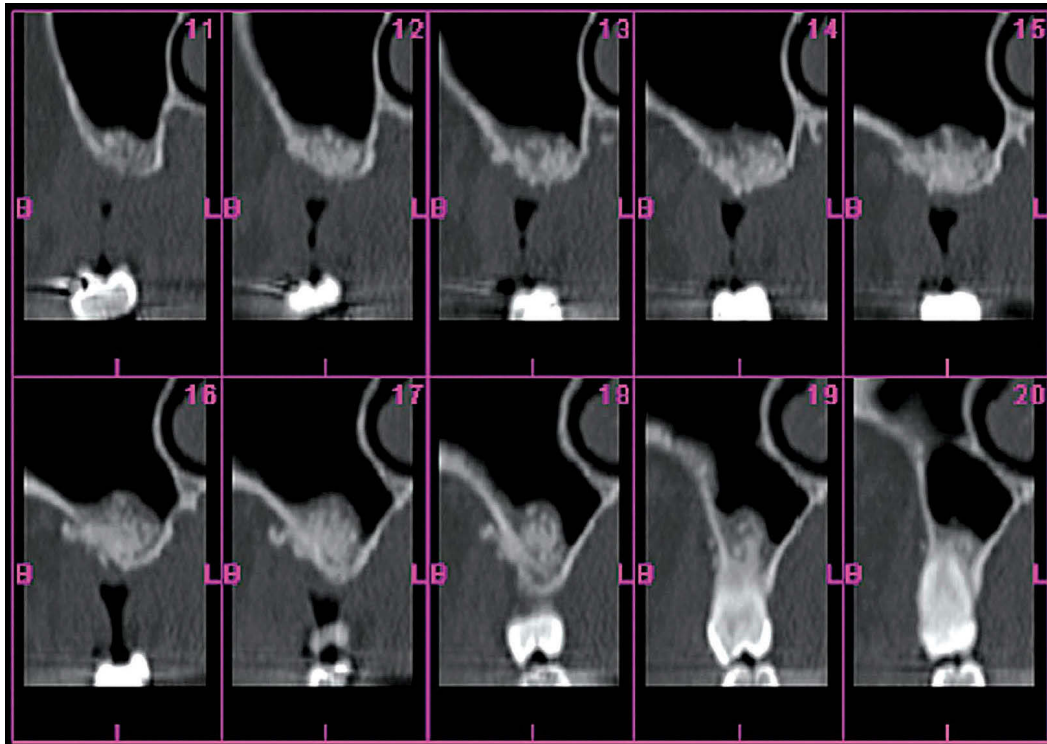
Sagittal CT scan reveals bone tissue in right posterior maxillary sinus previously pneumatized.
